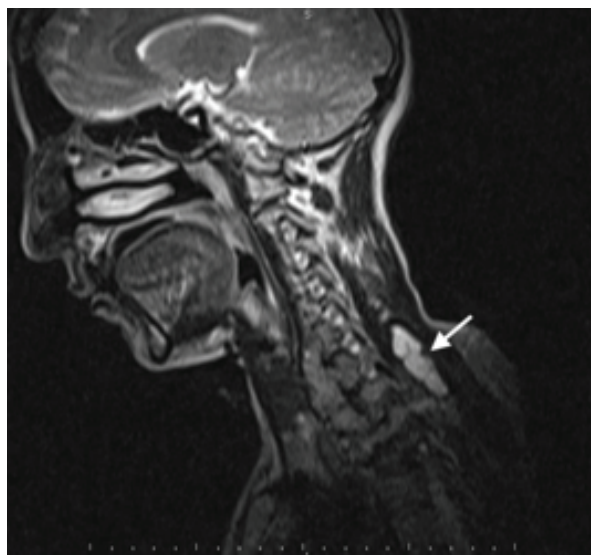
Hyperintense septation on T2-weighted sequences
